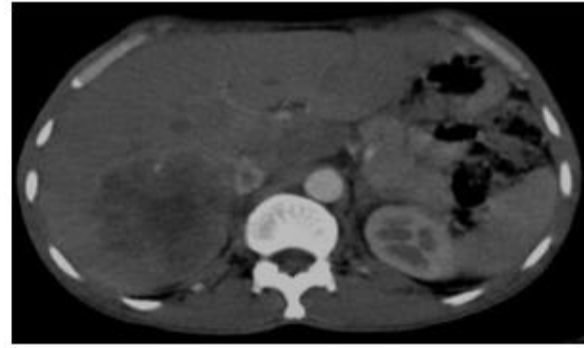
HCC CECT abdomen, showing heterogeneously enhancing lesion in arterial phase of triple phase CT.
